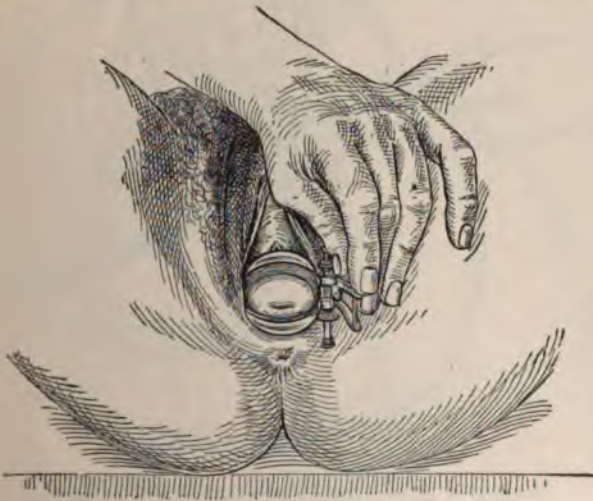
INDIRECT INSPECTION OF THE VAGINA.
